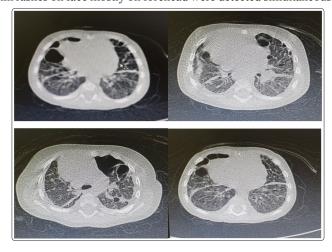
pneumothorax and multiple bilateral thin walled lung cysts were observed in high resolution CT scan (HRCT)
